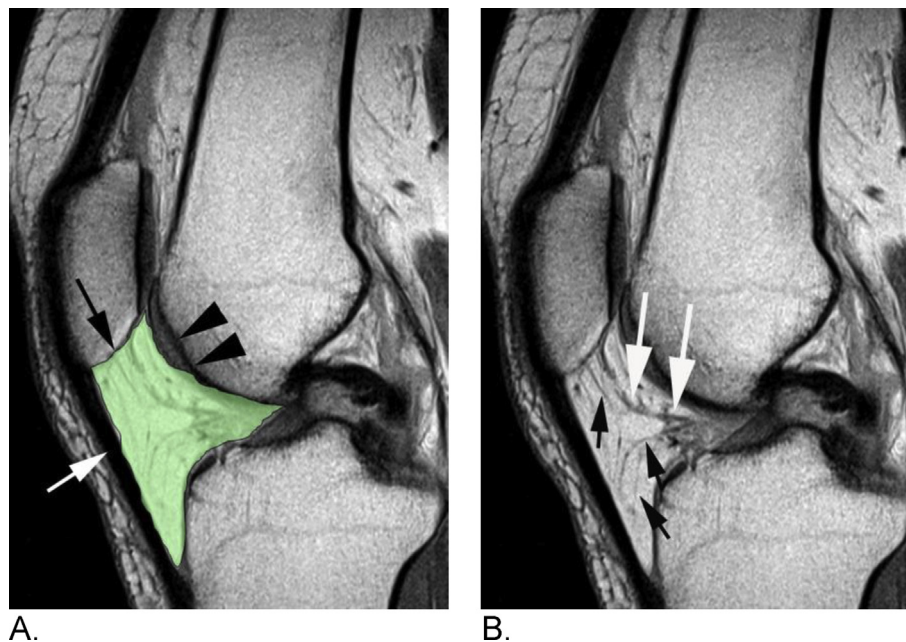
Anatomy of Hoffa's fat pad. A. Sagittal T1-weighted spin echo MRI. The IPFP is an intracapsular but extra-synovial structure (colored in green-transparent) limited by the patellar tendon anteriorly (white arrow), and the synovial-lined knee joint posteriorly. Superiorly it attaches to the inferior surface of the patella (black arrow), and projects posteriorly to the intercondylar notch via two alar synovial folds, which fuse forming the infrapatellar plica. Supero-posteriorly Hoffa's fat pad neighbors the cartilage of the femoral trochlea (black arrowheads). B. Identical image without overlay shows low signal foci seen within the fat pad that represent infrapatellar plica (white arrows) and vessels (small black arrows).
